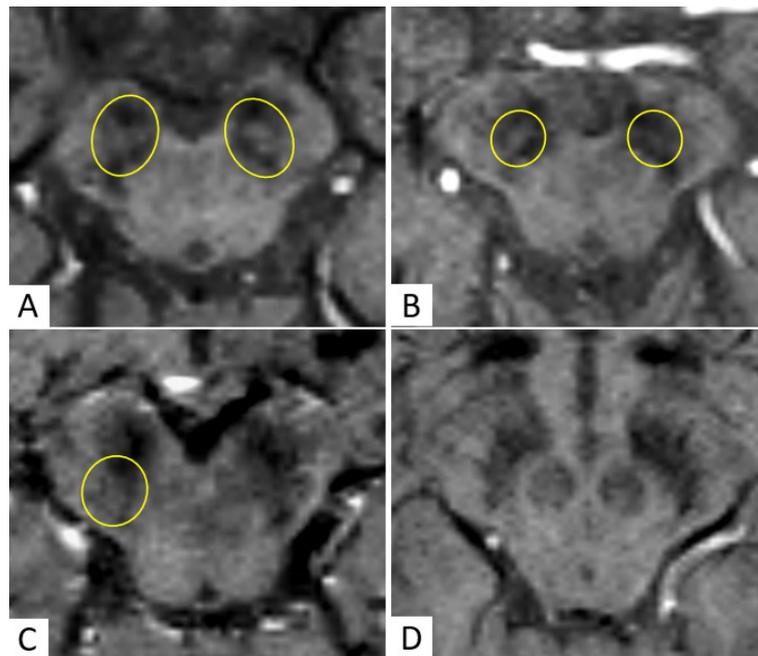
Susceptibility-weighted MR images in the axial plane; slices pass through the cerebral peduncles. The substantia nigra is hypointense on SWI sequences, whereas nigrosomes-1 (yellow circles) are hyperintense. The figure shows different patterns of nigrosome-1 appearance in patients with PD (A — 0 points, B — 1 point (nigrosome-1 is reduced in volume on the left), C — 2 points, D — 3 points)
